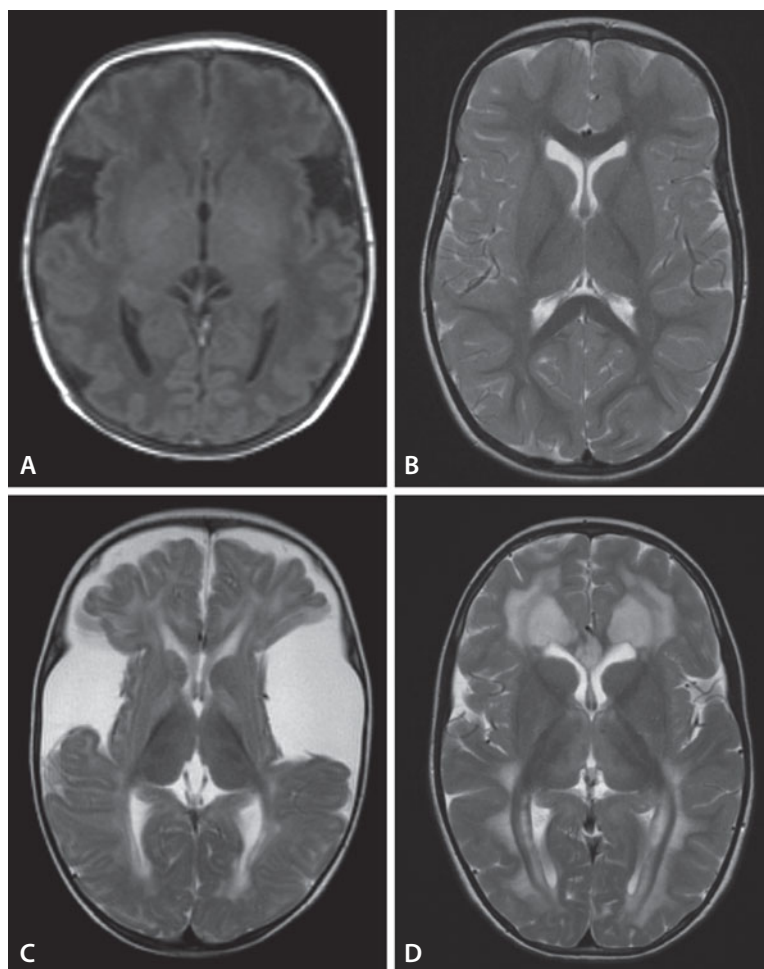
A–D, MRI findings in patients with glutaric aciduria type I. A, T1-weighted axial MRI of an asymptomatic male newborn with glutaric aciduria type I, showing enlargement of temporopolar and frontopolar CSF spaces and an immature gyration pattern. B, T2-weighted axial MRI of an asymptomatic 2-year-old girl identified by newborn screening. Previously dilated external CSF spaces and temporal hypoplasia have normalised. There is no pathology of the basal ganglia. C, T2-weighted axial MRI at age 7.5 months showing striatal atrophy and markedly dilated temporopolar and frontopolar CSF spaces. Signal abnormalities of globus pallidus, thalamus, and supratentorial white matter are also found. This child presented with moderate axial hypotonia, which progressed after a delay in the start of emergency treatment during an infectious disease. After a further 4 weeks, the child also developed dystonia of all extremities. D, T2-weighted axial MRI of a girl at age 11 years with suspected late-onset disease variant showing marked hyperintensity of the supratentorial white matter sparing the U fibres and mild to moderate signal changes of the caudate, thalamus, and dentate nuclei (not shown). The girl presented with nausea and vertigo at 10 years of age, which has improved following the start of carnitine supplementation and a protein-controlled diet. Motor and cognitive function is normal. (By courtesy of Dr Inga Harting and Dr Angelika Seitz)
